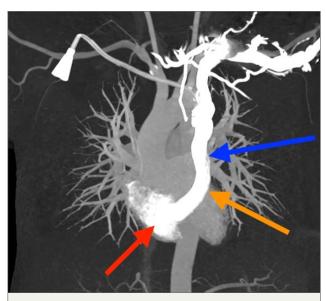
Computed tomography angiography. Maximum intensity projection computed tomography angiography coronal image demonstrating injection of contrast via the left subclavian vein, draining into the left-sided SVC (blue arrow) and into the right atrium (red arrow) via the coronary sinus (orange arrow).
